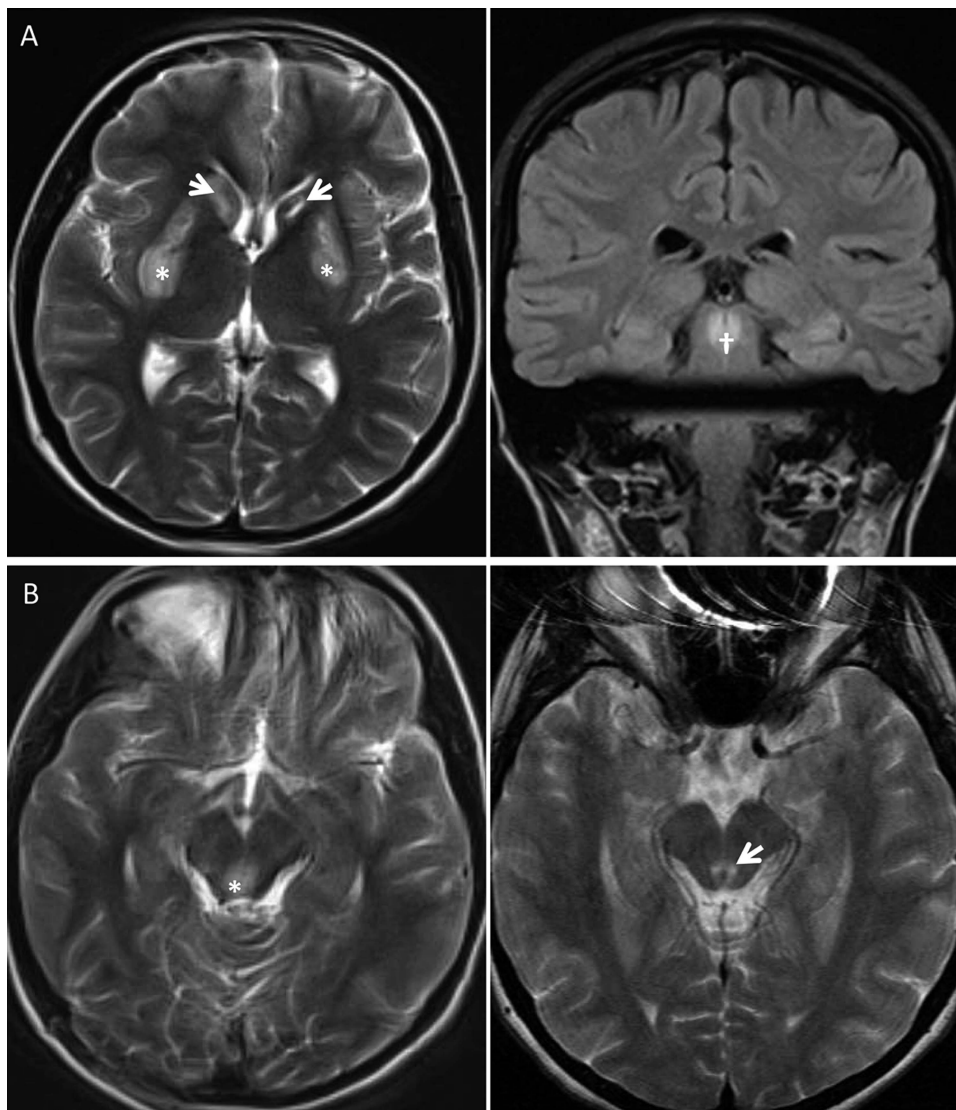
Initial axial (left) and coronal (right) T2-weighted images demonstrating signal abnormality and swelling of the caudate nuclei \nearrow , putamen* and periaqueductal region of the mid-brain† (A). Axial T2-weighted images before (left) and after (right) treatment showing the resolution of periaqueductal oedema* leaving some gliotic scarring in the mid-brain \nearrow (B).
